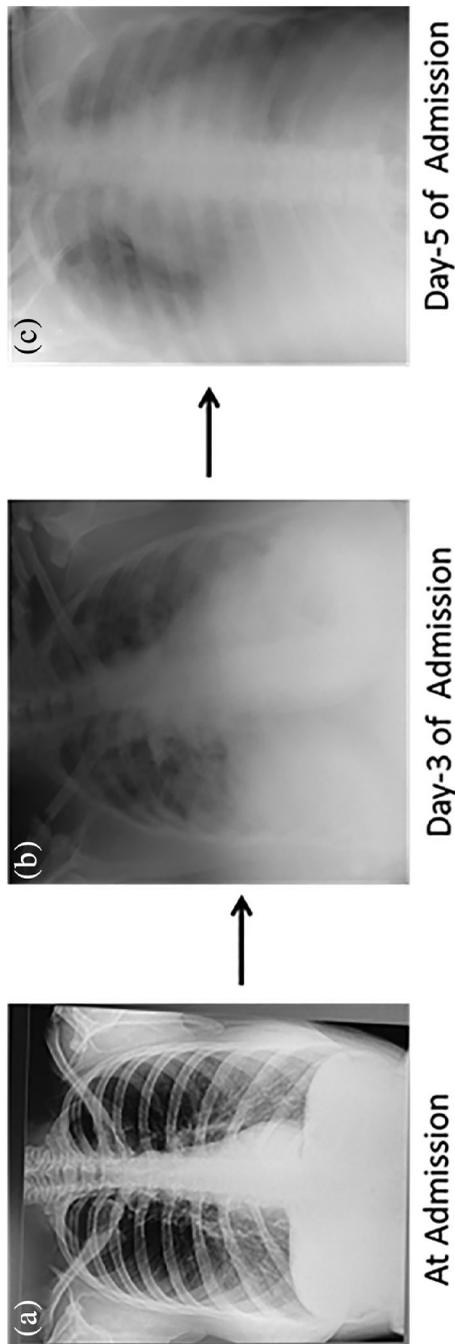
Series of chest X-rays showing rapidly progressing changes in the patient
